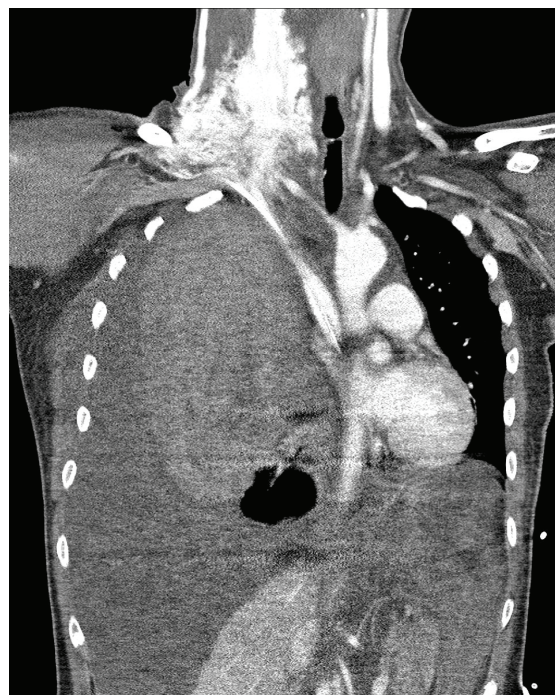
Postoperative chest computed tomography showing contrast media leakage in the right supraclavicular area and massive hemothorax.
